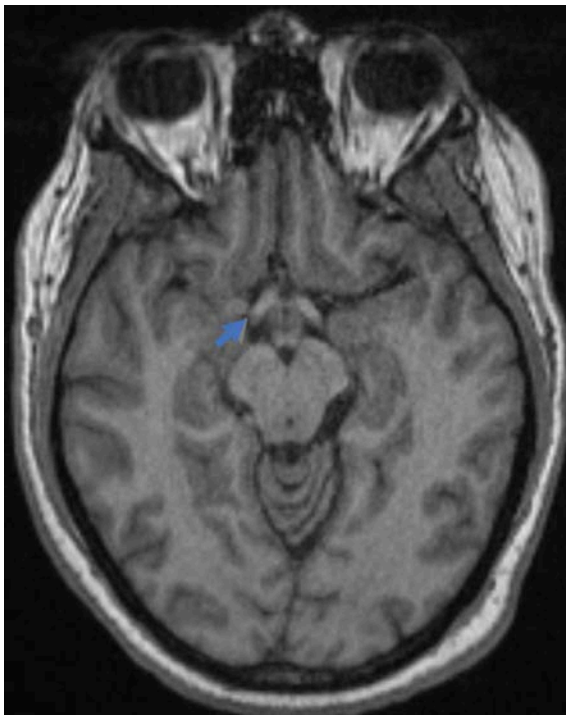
Brain MRI brain without contrast, axial
